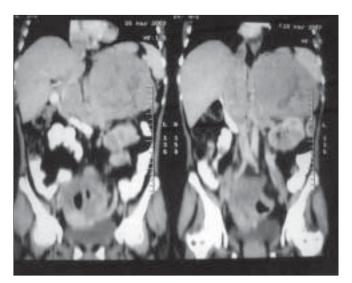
CT-scan showing heterogeneous solid mass in the left suprarenal region involving kidney and IVC
